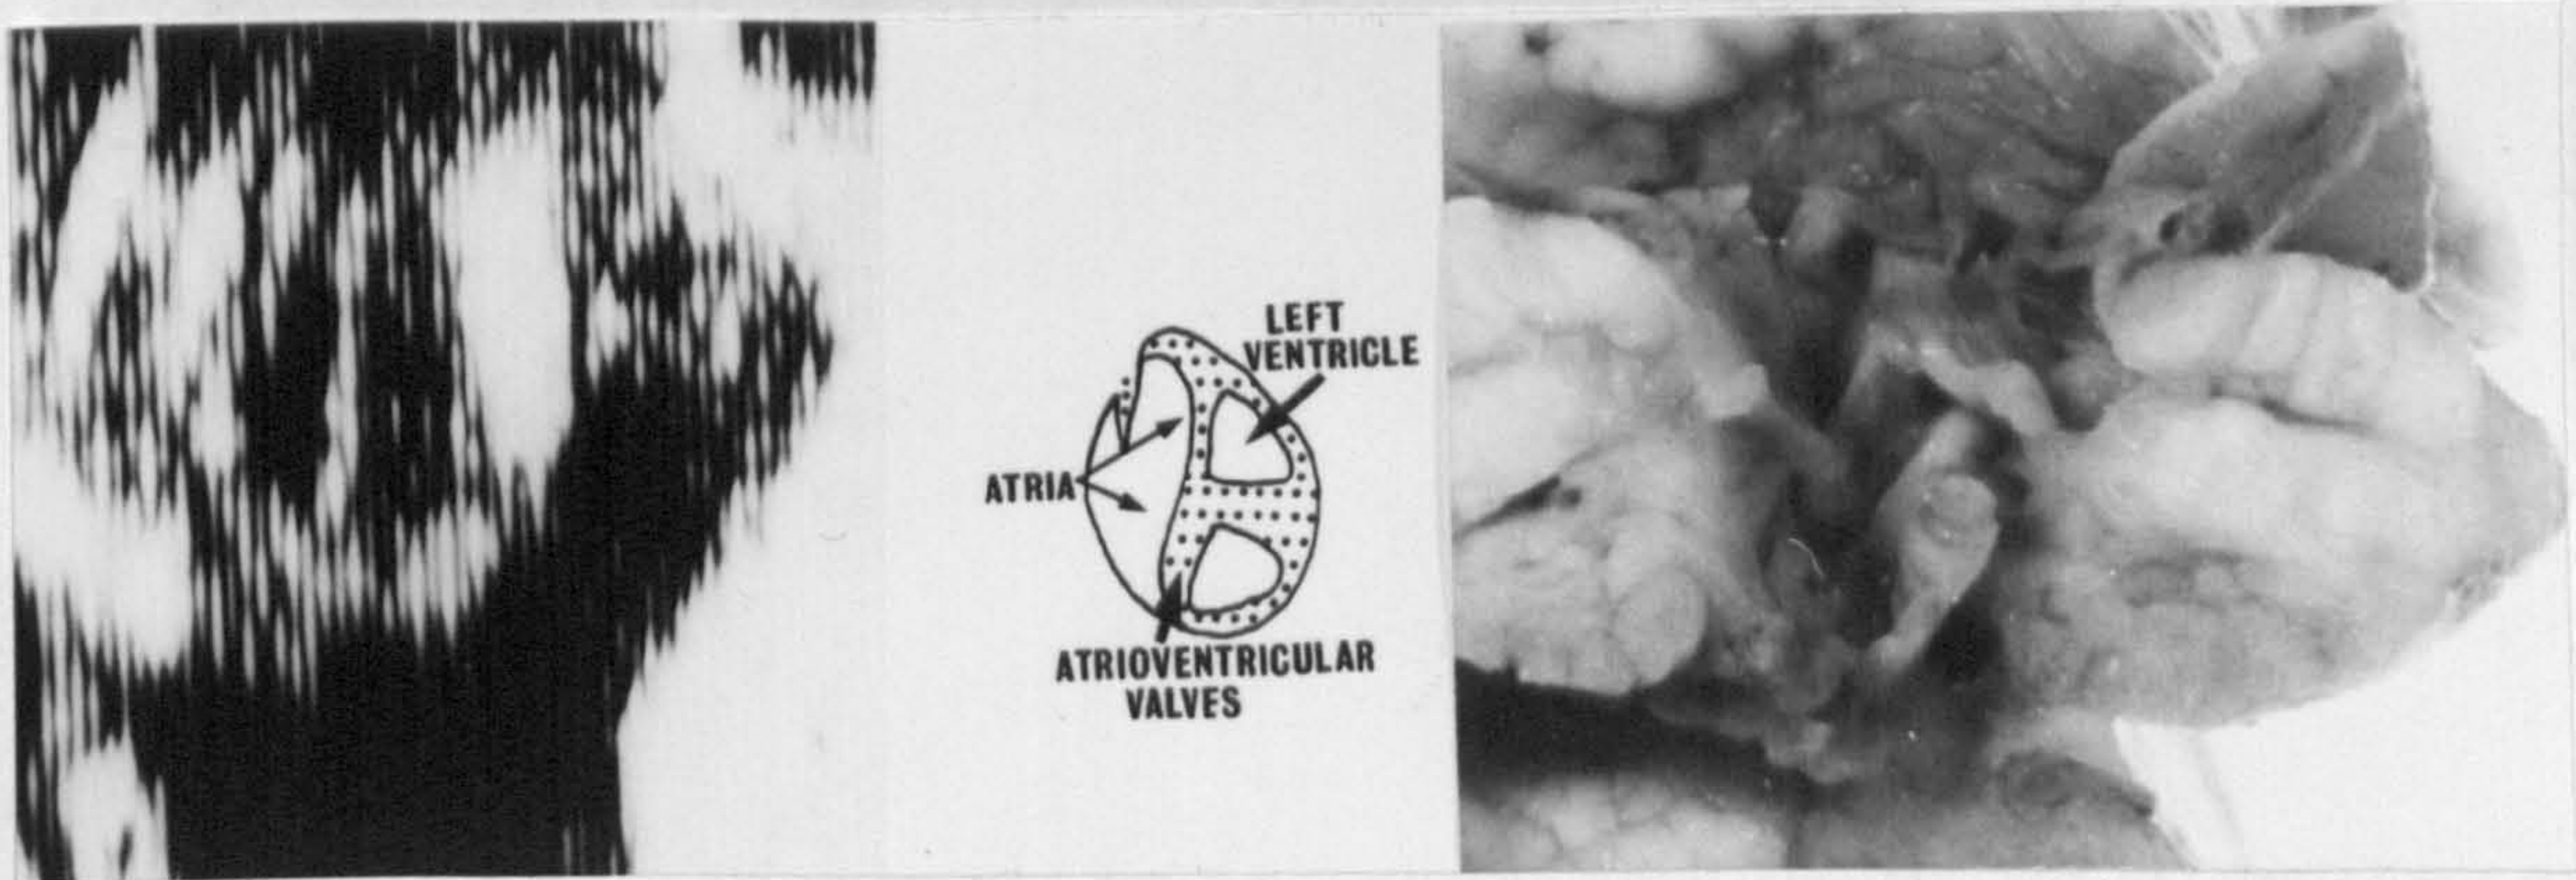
Case 1. The heart is seen echocardiographically and anatomically in the four chamber projection. The two atrioventricular valves are inserted equally on the septum. There was no atrial septum seen in the echocardiogram.
